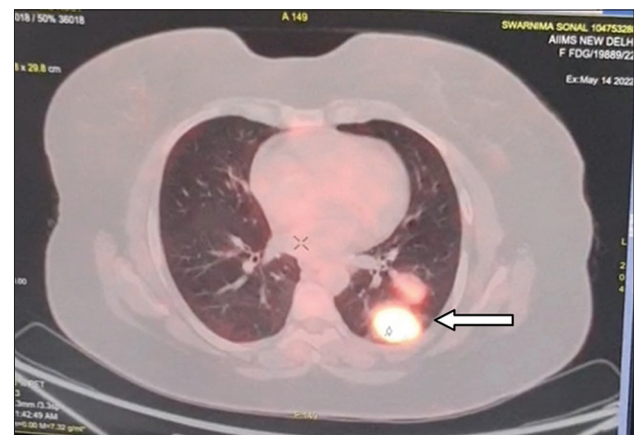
PET-CT scan showing two nodules in the left lower lobe of the lung (arrow), which are 2.8 × 2.5 cm in size.
